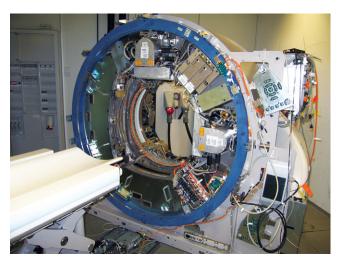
A dual-source multislice helical computed tomography imaging system. (Courtesy Jack Horwath, Siemens Medical Systems.)
